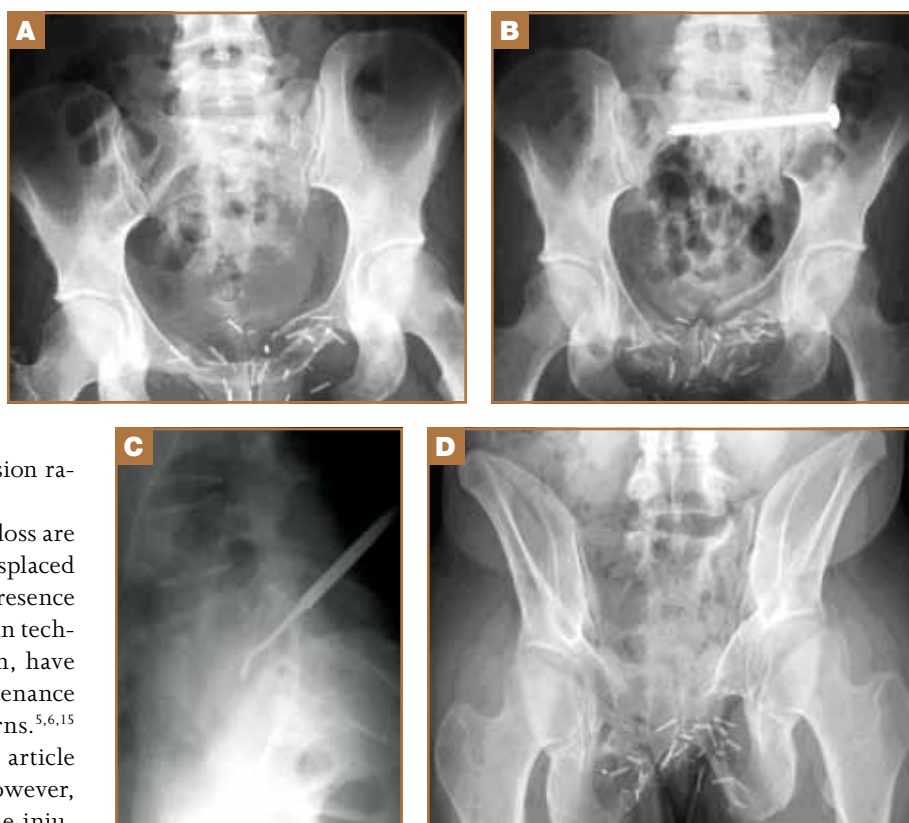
(A) Initial injury radiograph with superior displacement hemipelvis. (B) Redisplacement after iliosacral screw fixation. (C) Probe shows extent of ala removal. (D) Six-year follow-up.
